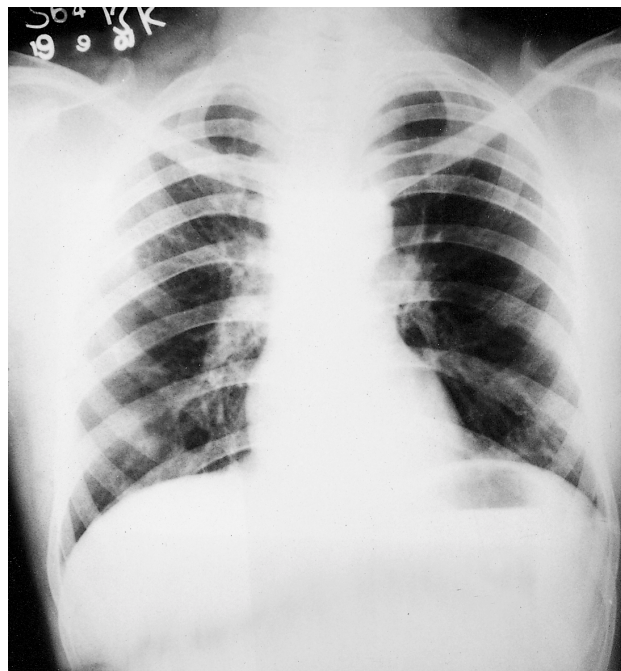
Clearing of the X-ray infiltrates after treatment.
